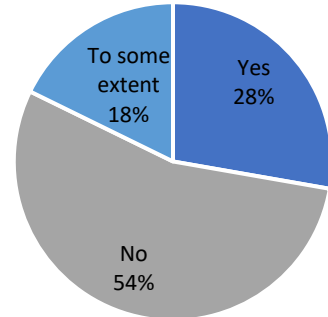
Ultrasound machine functional
